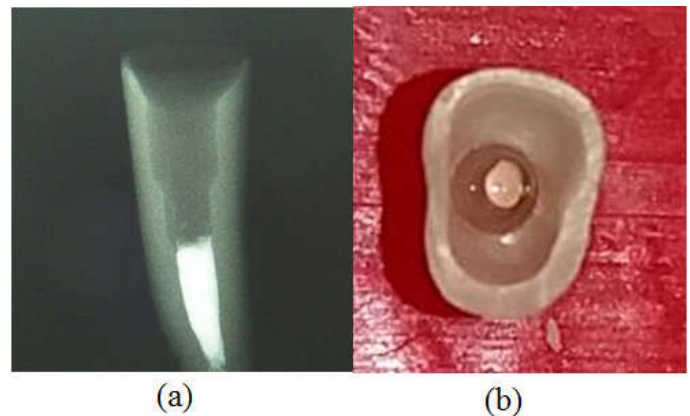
(a) X-ray showing a weakened root, (b) Occlusal view showing the cervical edge
